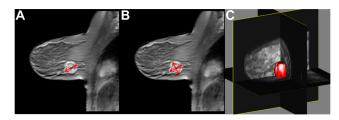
Figure I Lesion size measurement by MRI. (A) Unidimensional measurement of tumor long axis diameters. (B) Bidimensional measurement of tumor long and short axis diameters. (C) Three-dimensional measurement of tumor volume. Abbreviation: MRI, magnetic resonance imaging.
